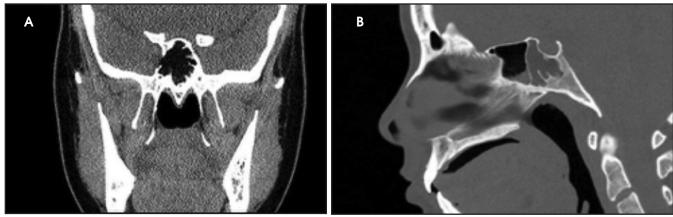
Coronal (A) and sagittal (B) CT images demonstrate expansile lytic sphenoclival lesion containing fat.
